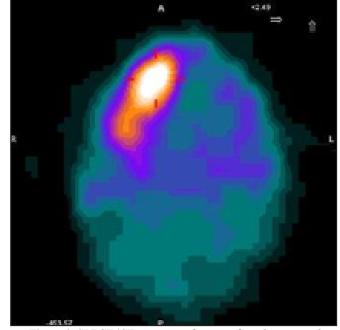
SPECT/CT images confirm significantly increased galium tracer uptake in the body of mandible when compared to MDP tracer.
